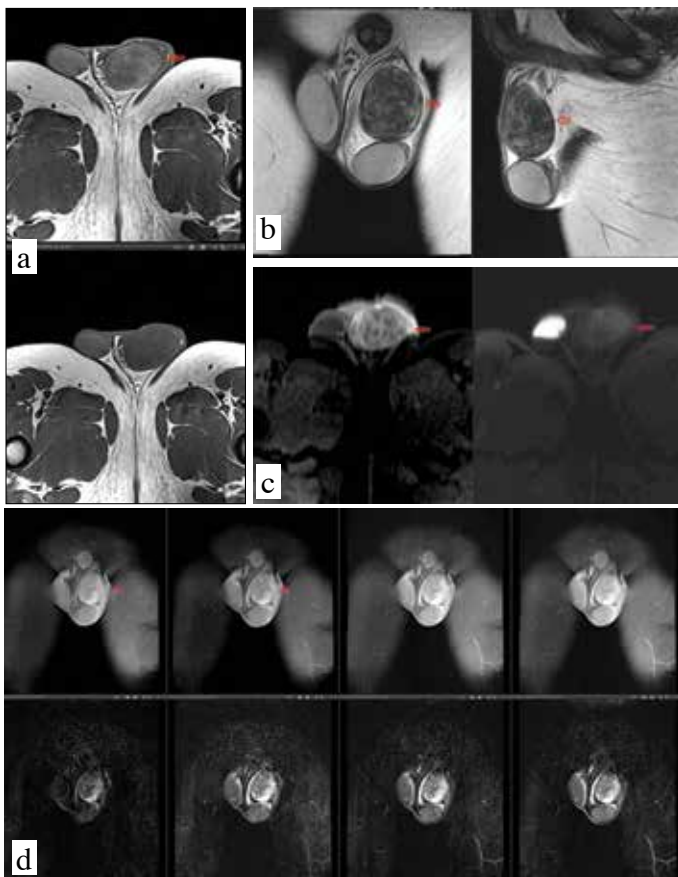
a-d. A heterogeneously hypointense extratesticular mass lesion in the left scrotum is seen on axial (a) and coronal-sagittal (b) T1 and T2-W images in testicular MRI. Mild diffusion restriction was observed (c). Heterogeneously increased contrast enhancement at the early arterial phase is seen on dynamic contrast-enhanced examination (d)
